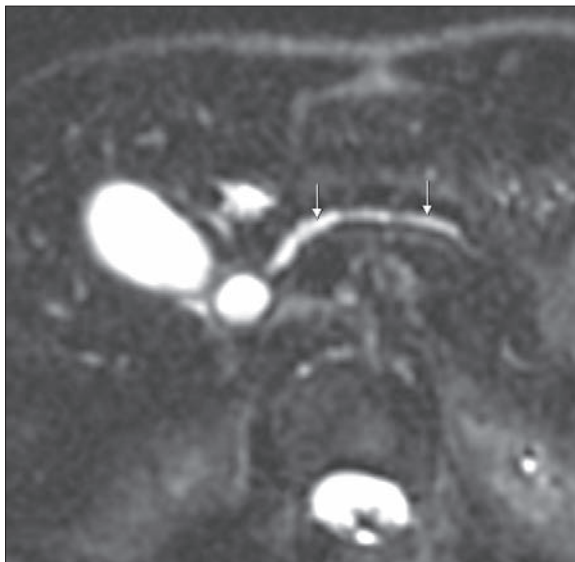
MRCP. Axial heavily T2-weighted ("thin slab" technique) image. Pancreatic duct dilatation visualized (arrows).
